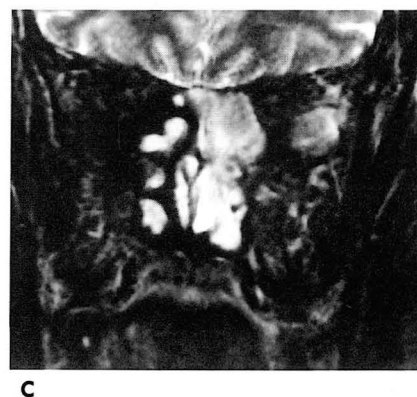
Sphenchoanal polyp. Axial CT scans (A) shows the sphenoid sinus filled with soft tissue density. Coronal CT scan (B) shows widened sphenoid sinus ostium by the polyp(arrow), which extends into the nasal cavity. Coronal T2-weighted MR image (C) shows less bright signal intensity of the sinus component than that of the nasal component.
